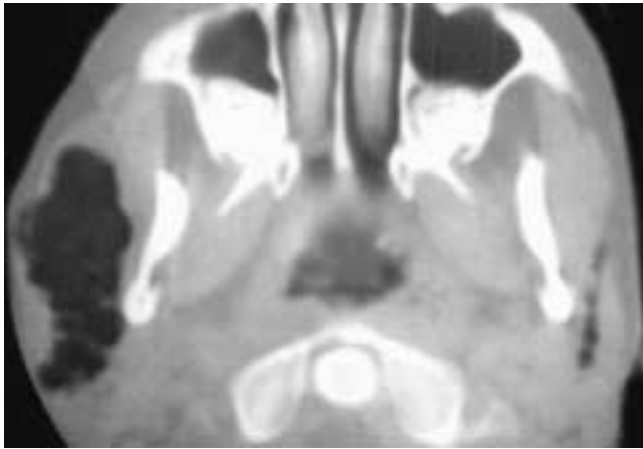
Axial CT scan shows a considerable amount of air in the right parotid gland and a small amount of air in the left parotid gland. This child had bilateral pneumoparotitis.
